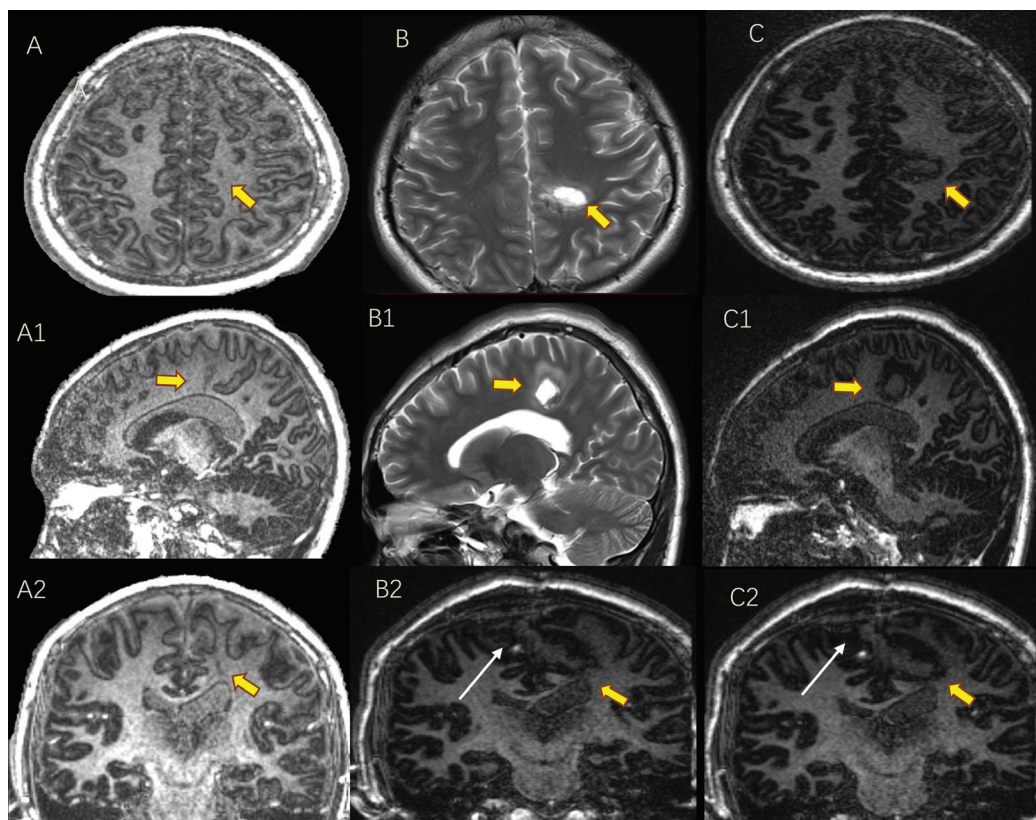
We choose the right parietal interhemispheric approach to reach the lesion (white arrow B2, C2). (A–A2) 3D-EDGE transverse, sagittal and coronal view of the lesion. Postoperative MRI images showed complete resection of the lesion. (B–B1) Postoperative T2-TSE images transverse, sagittal view. (C–C2, B2) Postoperative 3D-EDGE imaging the same level of lesion transverse, sagittal, and coronal view. 3D-EDGE, three-dimensional edge-enhancing gradient echo; MRI, magnetic resonance imaging; TSE, transmissible spongiform encephalopathies.
